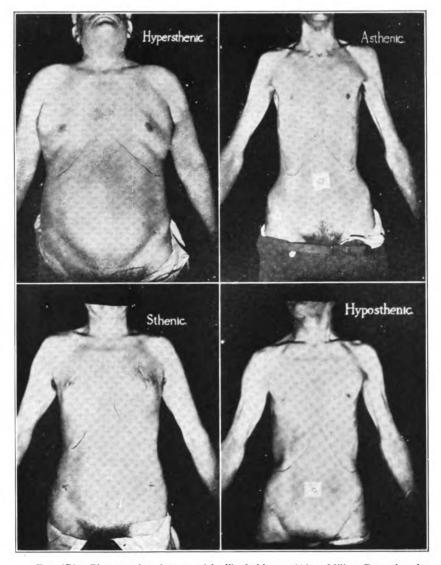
Photographs of types of bodily habitus. (After Mills. Reproduced through the courtesy of the American Journal of Roentgenology and Radium Therapy.)
